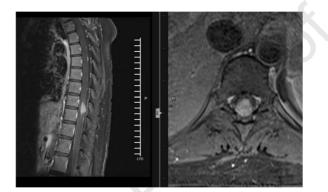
MRI thoracic spine T1 with contrast Axial Cut, sagittal cuts
